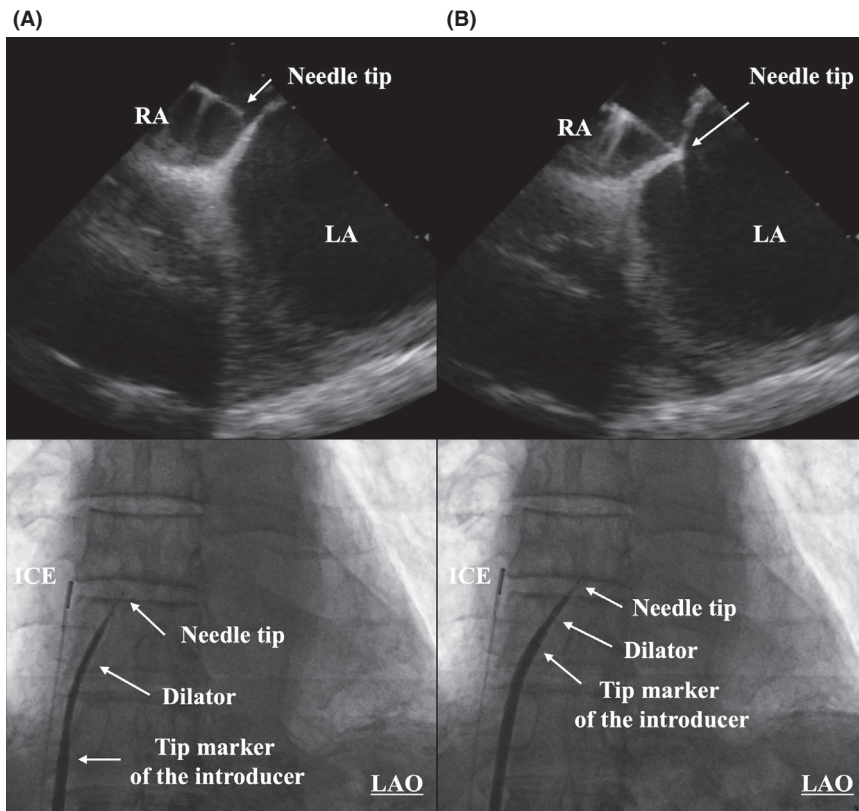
Intracardiac ultrasound and fluoroscopic images exhibiting radiofrequency transeptal puncture before (A) and after applying in situ needle deflection technique using the steerable introducer (B). Note that the distance between the needle tip and the intracardiac echocardiography (ICE) catheter. LA, left atrium; LAO, left anterior oblique projection; RA, right atrium
